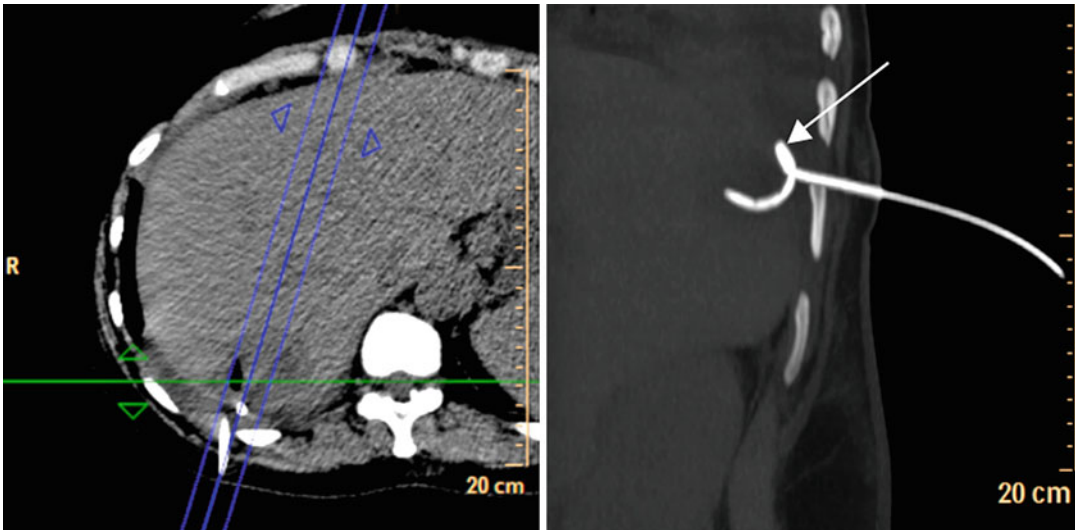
Control CT after insertion of a drainage catheter for the treatment of a liver abscess. The *left image* shows an axial image at the level of the abscess. The corresponding
